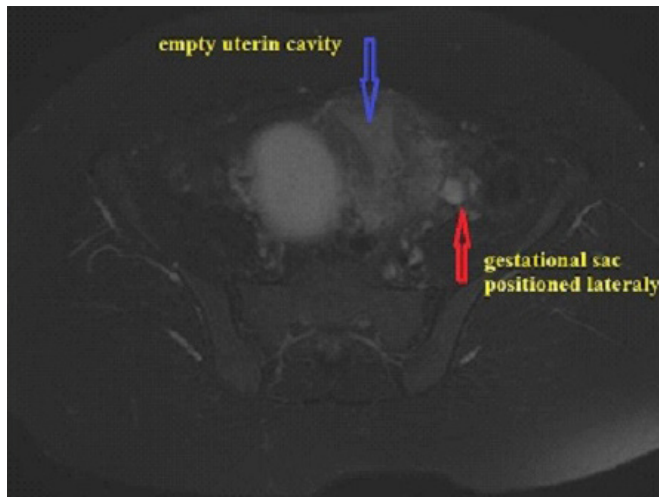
T2A-Axial and sagittal MRI Images. Empty endometrial cavity and cervical canal. Blue arrow shows empty endometrial cavity and red arrow shows gestational sac positioned anterolaterally.
